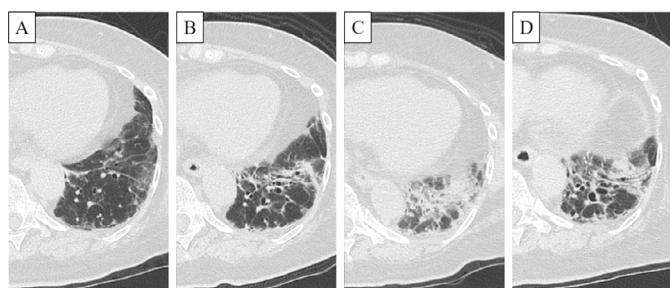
Computed tomography (CT) shows that the reticular shadows in the left lower lobes worsened from 18 weeks (A) to 48 weeks (B) after the onset. CT shows consolidation in the left lower lobes 72 weeks after the onset (C). CT shows that consolidation in the left lower lobes was reduced at 86 weeks after the onset (D).
